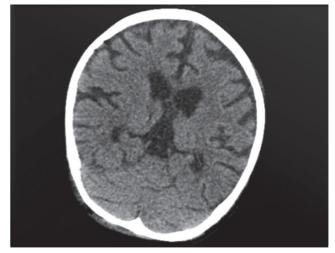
Cerebral and cerebellar atrophy, deepening of the cerebral sulci on cranial computed tomography in case 3
